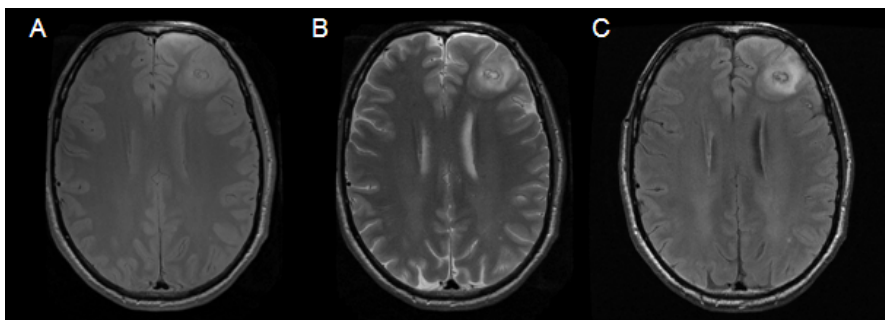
T1-weighted MR images of a patient with GBM
